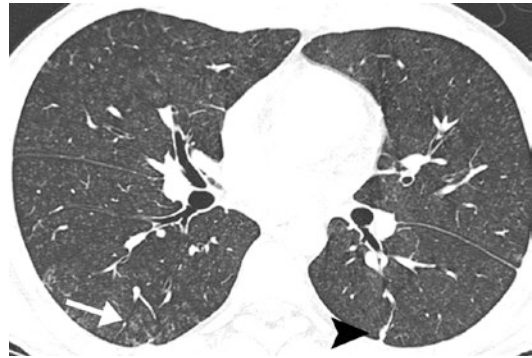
Goodpasture syndrome in a 21-year-old man. CT scan shows multiple nodules, subtle ground-glass opacities (*arrow*), and mild interlobular thickening (*arrowhead*)
